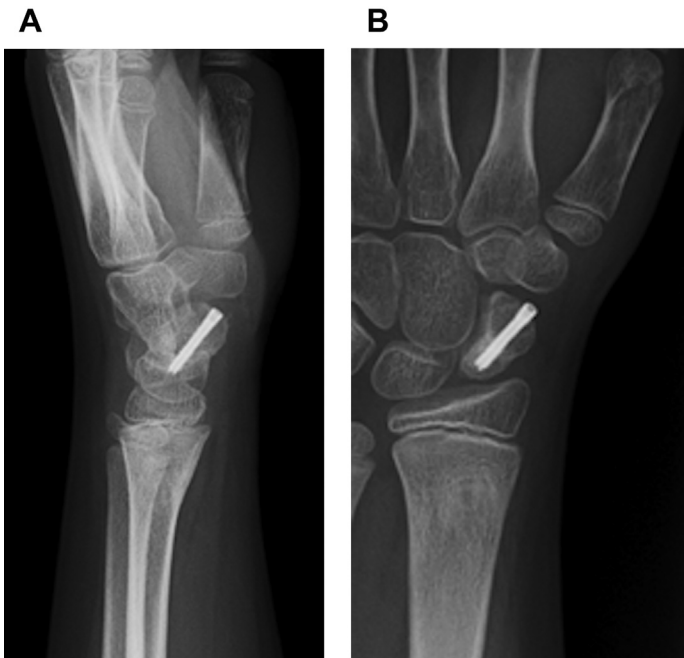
Nondisplaced scaphoid fracture. Nondisplaced scaphoid fractures in children are treated with immobilization, or if the needs or wishes of the child and family require it, percutaneous screw fixation. Lateral (A) and posteroanterior (B) radiographs demonstrate a retrograde screw placed via an anterior approach because of incomplete ossification of the proximal pole in this 13-year-old boy. (Courtesy of Shriners Hospital for Children Philadelphia.)
